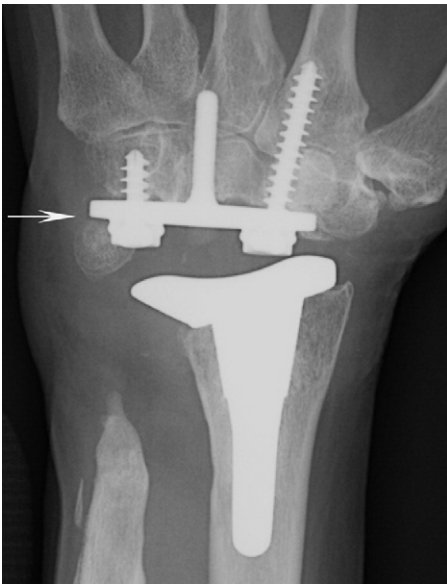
Postoperative, posteroanterior radiograph showing excellent position of a total wrist arthroplasty implant. A white arrow highlights the area of potential pisiform/carpal base plate impingement.
